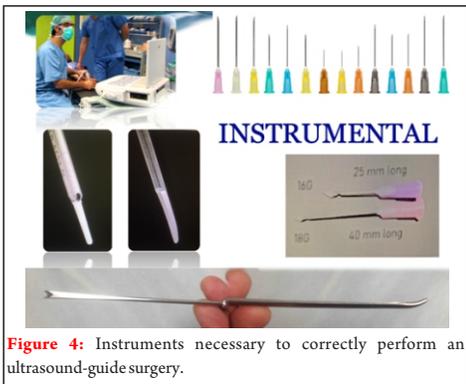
Instruments necessary to correctly perform an ultrasound-guide surgery.
